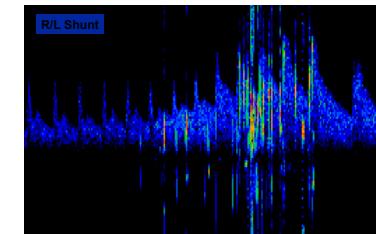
Doppler sonographic imaging of the middle cerebral artery. Multiple bubble signals after injection of Echovist® at rest: right-to-left Shunt of high hemodynamic relevance.
